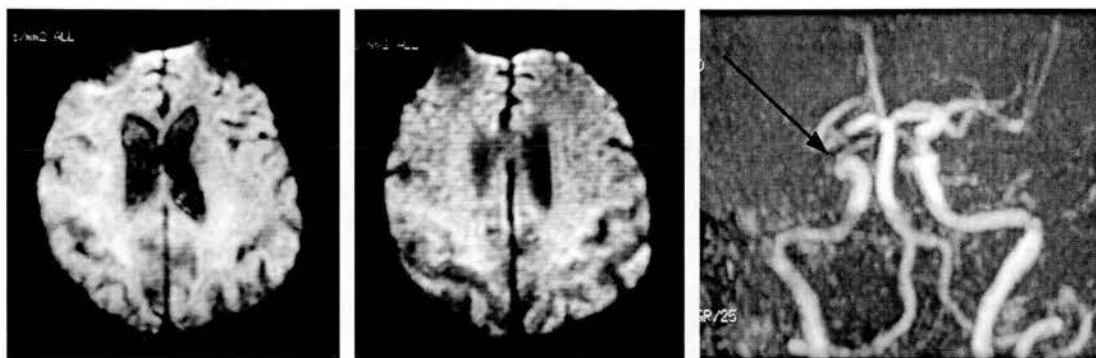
A patient with a clinical TACS and an appropriate middle cerebral artery occlusion yet a normal DWI
